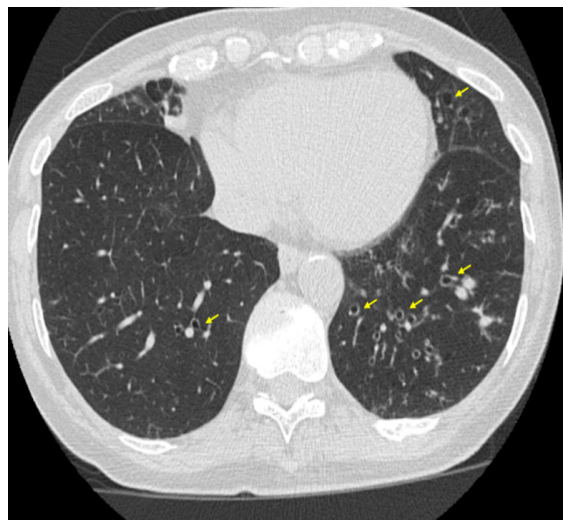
Computed tomography (CT) of the chest showing multifocal cylindrical bronchiectasis (yellow arrows), predominantly in the left lower lobe.
